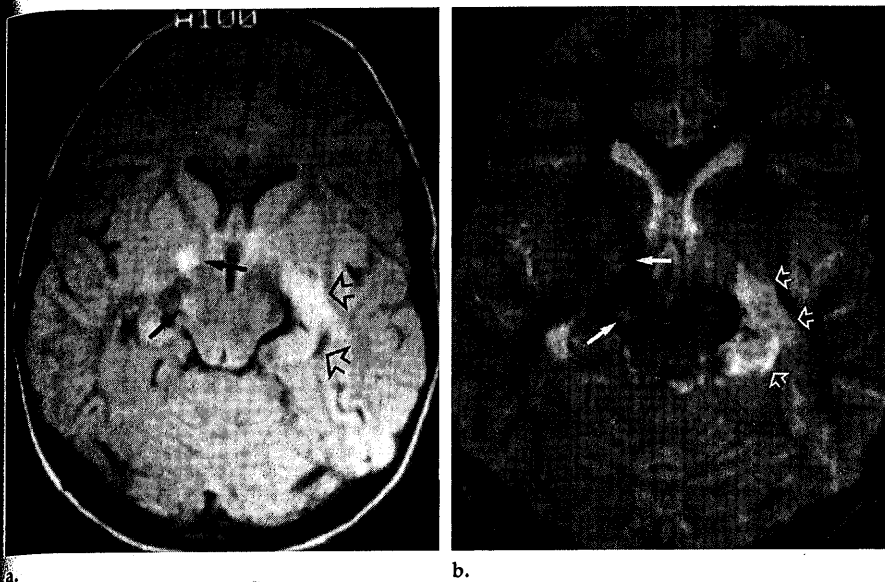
Patient 2. (a) Axial long TR/short TE (2,500/30) and (b) long TR/TE (2,500/80) MR images demonstrate focal hyperintensities in the right globus pallidus, internal capsule, and crus cerebri (solid arrows). Increased signal intensity in the medial left temporal lobe (open arrows) is related to the patient's anaplastic astrocytoma, which was diagnosed at autopsy.
